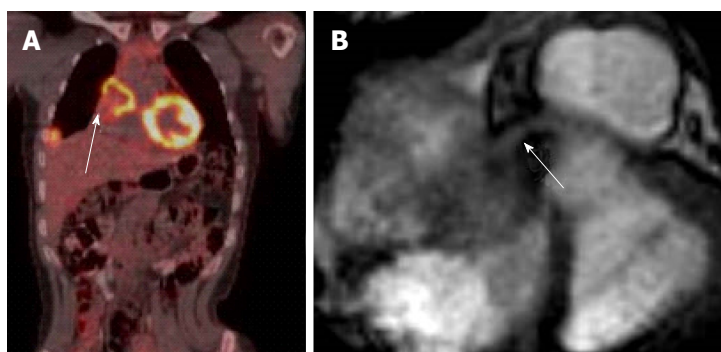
Evaluation of coronary artery involvement by the tumor. A: Coronal PET-CT image in a female patient with history of breast cancer with mediastinal and lung metastasis and recurrent chest pain; B: Axial cine image at the base of the heart shows metastatic lesion invading the heart causing mechanical obstruction of the right coronary artery (arrow). PET: Positron emission tomography; CT: Computed tomography.
